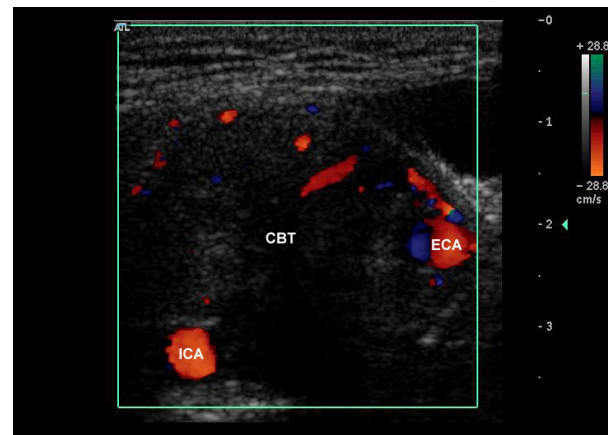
Duplex ultrasound – transverse view: the internal and external carotid arteries are separated by the tumour. ICA, internal carotid artery; ECA, external carotid artery; CBT, carotid body tumour.
